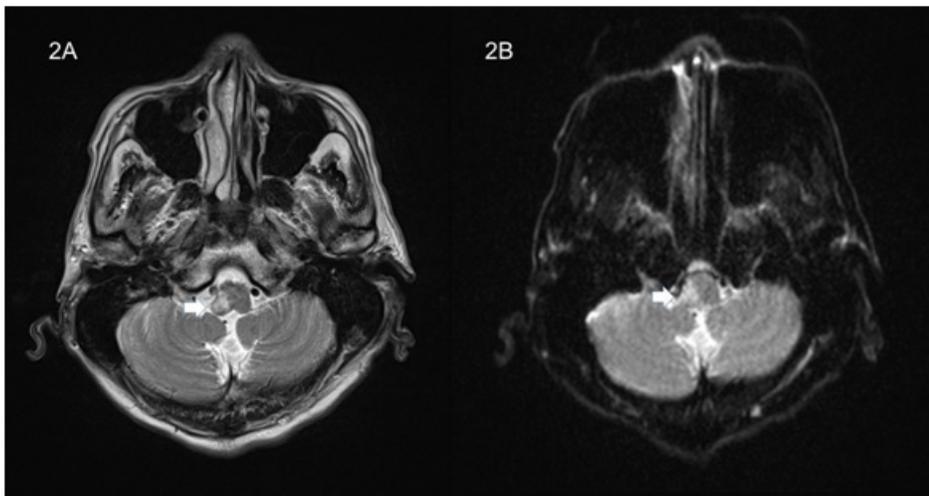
Hyperintensity seen (arrow) during T2W/ fluid-attenuated inversion recovery (FLAIR) at right lateral medulla oblongata.
